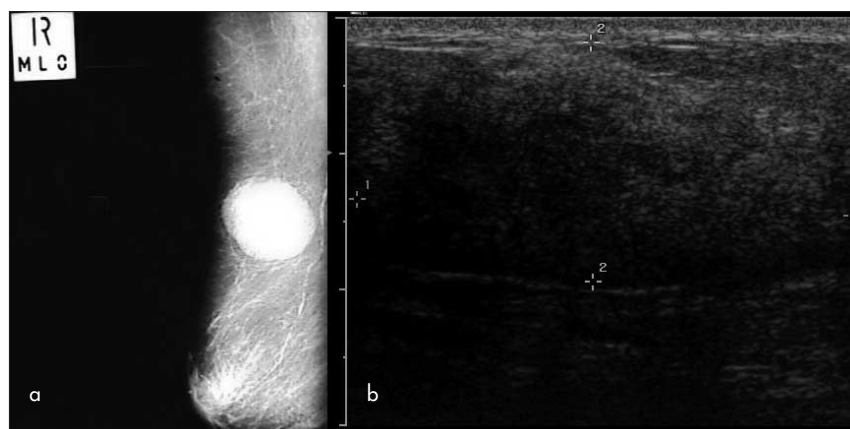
a. Mammogram of the right breast demonstrating a well-circumscribed soft tissue mass in the upper, outer quadrant consistent with pseudoangiomatous hyperplasia of mammary stroma. b. An ultrasound scan of the same lesion, measuring 3.6 x 1.8 cm as marked, which is relatively hyperreflective compared to surrounding parenchyma.
